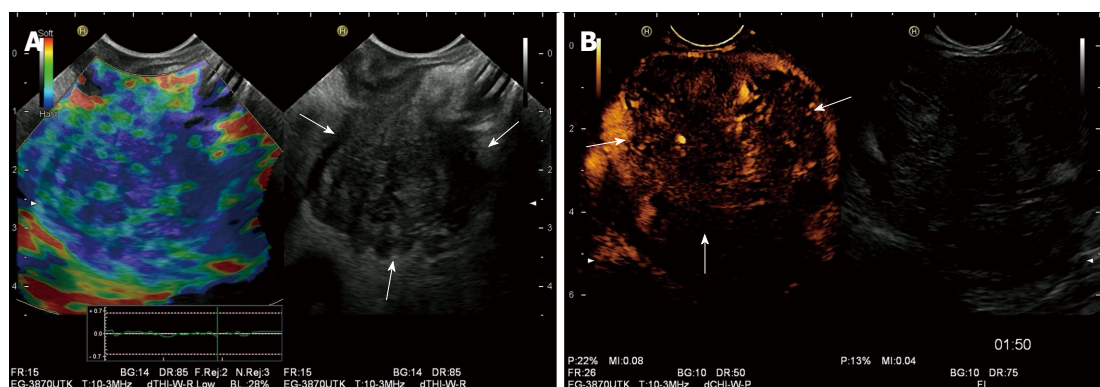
Combination of elastography and contrast-enhanced ultrasound in endoscopic ultrasound. A: A pancreatic ductal adenocarcinoma is demonstrated as a heterogeneous hard (blue) pattern; B: On contrast-enhanced endoscopic ultrasound, pancreatic ductal adenocarcinoma is hypo-enhancing.
